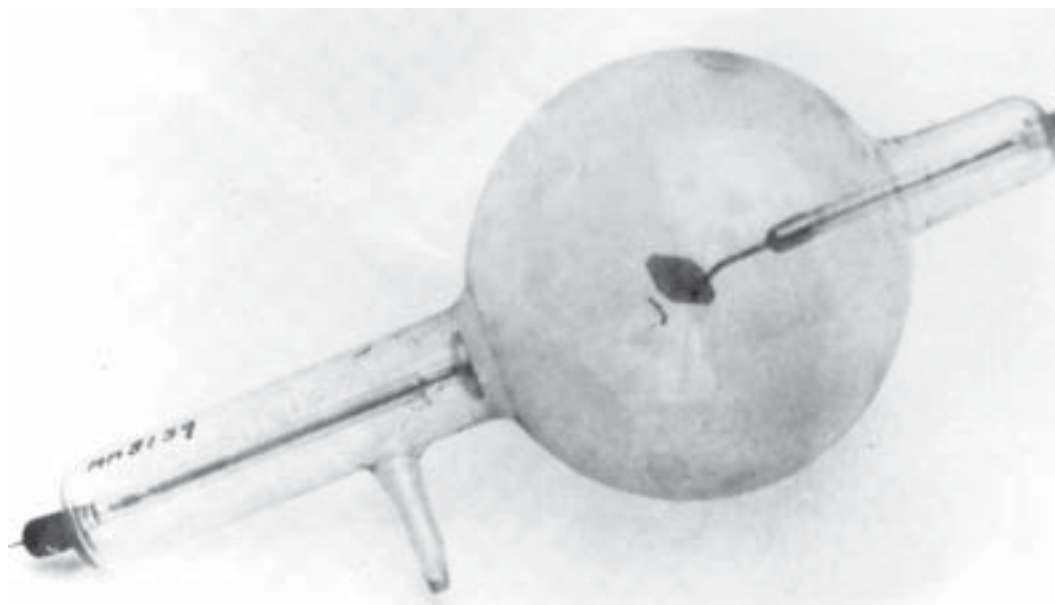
A roentgen-ray tube similar to the one possessed by the U.S. Army Medical Museum that was used to locate a bullet lodged in a patient in 1896. Crude tubes of this type were the first X-ray machines used by the U.S. Army. Source: Henry RS. *The Armed Forces Institute of Pathology, Its First Century 1862-1962*. Washington, DC: Office of The Surgeon General, DA, 1964.
